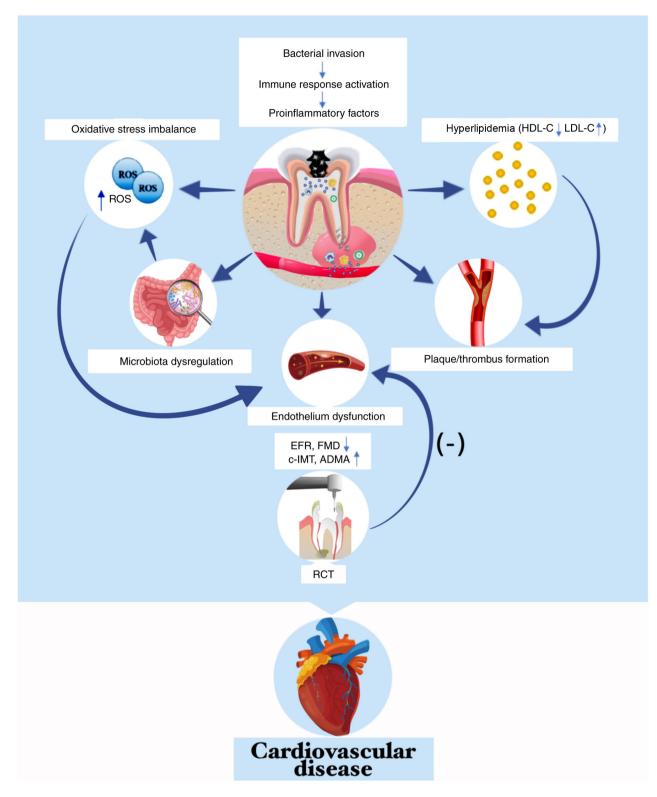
Apical periodontitis accelerates progression of cardiovascular disease. Bacteria and/or their products in the periapical region are transferred to systemic circulation, which can activate the systemic immune response and promote the secretion of pro-inflammatory factors, eventually causing dysbiosis of the intestinal flora, aggregating overloads of ROS and/or developing into hyperlipidemia. Elevated serum inflammatory factors and lipids contribute to plaque/thrombus formation. Excessive ROS and inflammatory mediators directly damage vascular endothelium, impairing FMD and EFR and increase c-IMT and concentration of ADMA. Conversely, root canal treatment improves early endothelial dysfunction. EFR, endothelial flow reserve; ROS, reactive oxygen species; HDL-C, high density lipid-cholesterol; LDL-C, low density lipid-cholesterol; FMD, flow-mediated dilatation; c-IMT, carotid intima-media thickness; ADMA, asymmetrical dimethylarginine.
